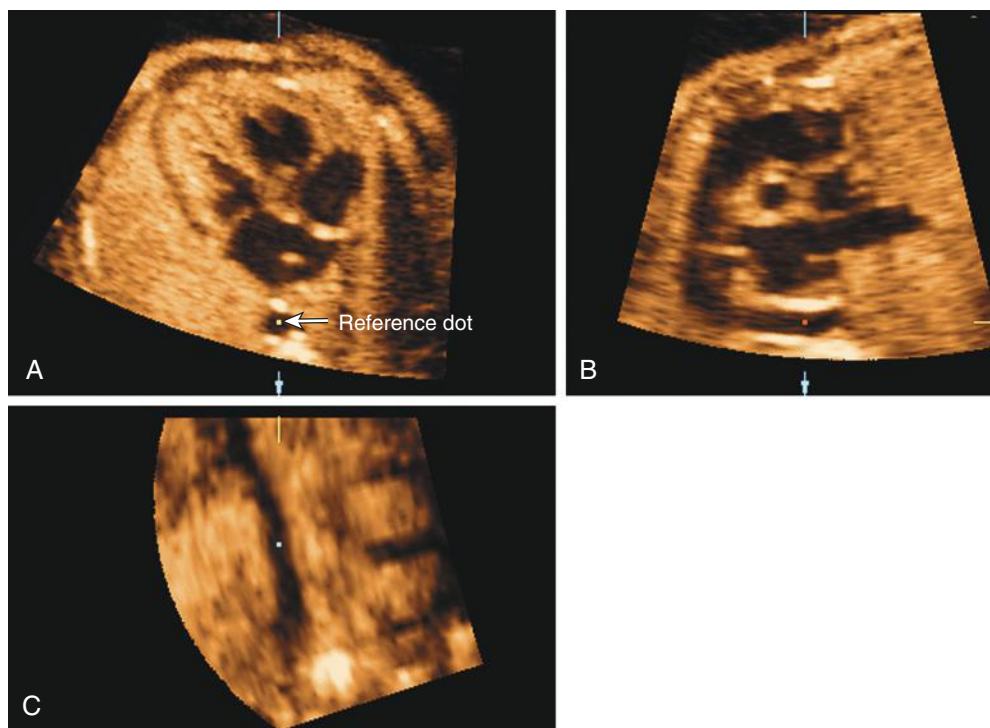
Multiplanar display in three- and four-dimensional sonography allows for the simultaneous display of three anatomic planes that are orthogonal to each other: the transverse (A), sagittal (B), and coronal (C) planes. An imaging tool referred to as the reference dot allows for the identification of anatomic structures in these three orthogonal planes.
